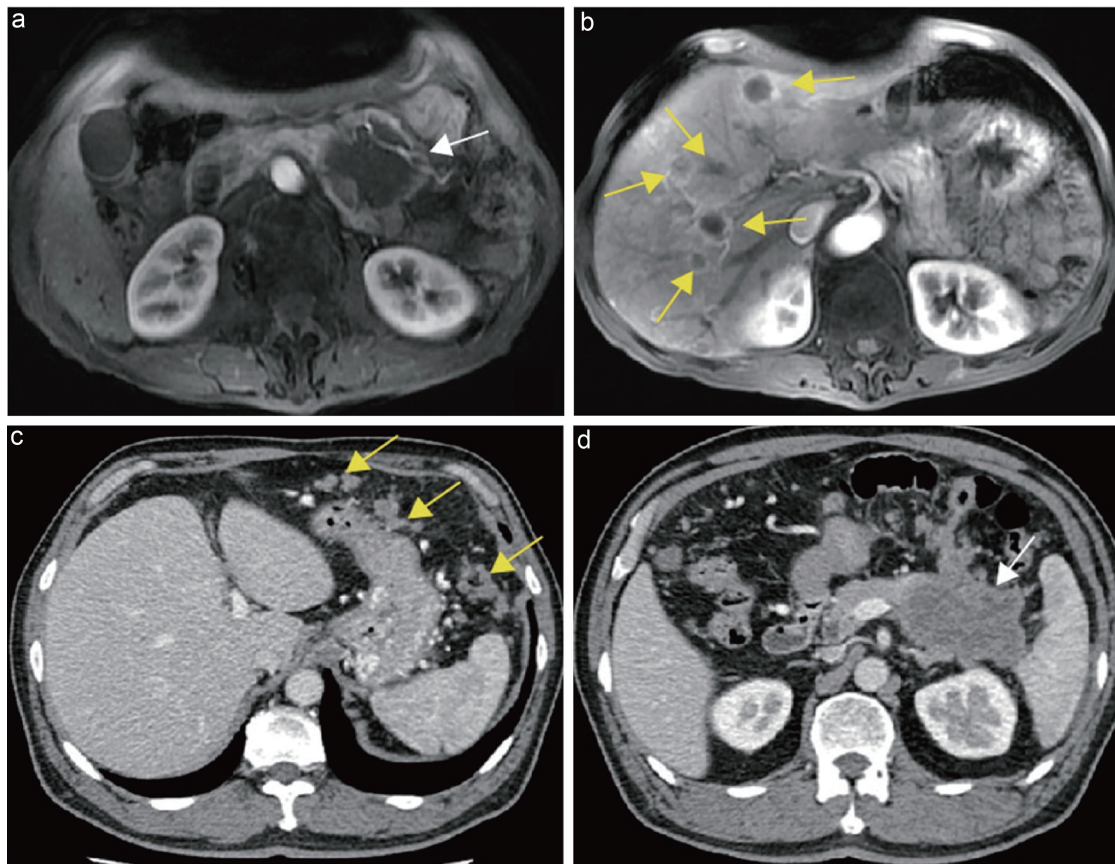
Evaluation of hepatic and distant metastases in pancreatic cancer. a, b Same patient. (a) Axial portal venous–phase T1-weighted MRI showing a hypointense mass in the pancreatic body and tail (white arrow). (b) Axial portal venous–phase T1-weighted MRI showing multiple ring-enhancing lesions in the liver (yellow arrows), consistent with hepatic metastases. c, d Same patient. (c) Axial portal venous–phase CT showing a hypodense mass in the pancreatic body and tail (white arrow). (d) Axial portal venous–phase CT showing nodular changes of the omentum (yellow arrow), consistent with omental metastases. CT, computed tomography; MRI, magnetic resonance imaging.
